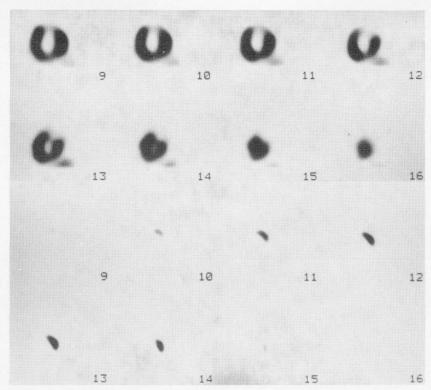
Short axial reconstructions from simultaneous thallium-201 chrolide (top) and technetium-99m pyrophosphate (bottom) SPECT acquisitions from patient 11. The threshold level of thallium-201 (Tl-201) was 30% and that of technetium-99m pyrophosphate (Tc-99m PYP) was 70%. The uptake of Tl-201 was reduced in the anterior and anterolateral walls, and the uptake of Tc-99m PYP was observed in the same region. The infarct size obtained from Tc-99m PYP was 7.3 ml.
